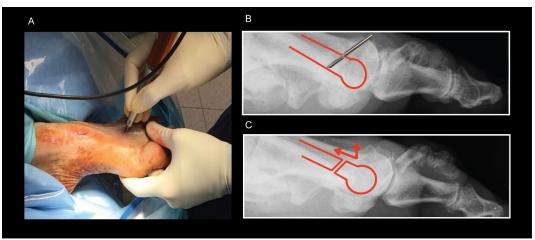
A DMO is performing by a 12-mm Shannon Isham burr with an angle of approximately 45° with respect to the long axis of the lesser MB in a dorsal-distal to proximal-plantar direction (A). Lateral view X-rays of a left DF on weightbearing before (B) and after (C) the osteotomy performed proximal to the neck with potentially greater elevation of MH from the ground
